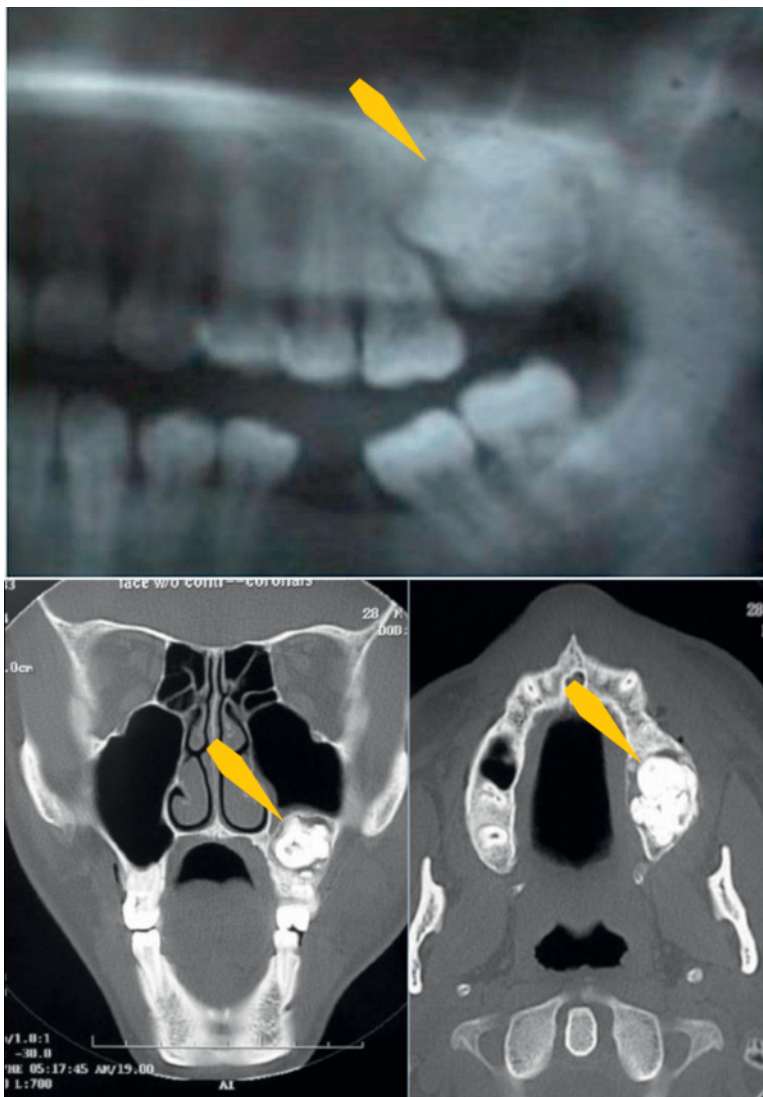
Comparison of pantographic radiograph (top) and computed tomography (bottom) images of a compound odontoma (arrows). Note the expansion into the sinus floor and the radiolucent fibrous capsule surrounding the lesion.
